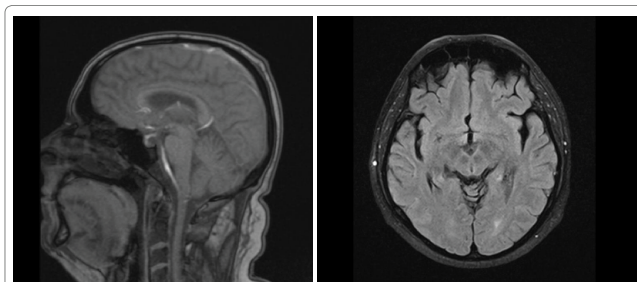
Magnetic resonance imaging (MRI) of the brain was negative.
